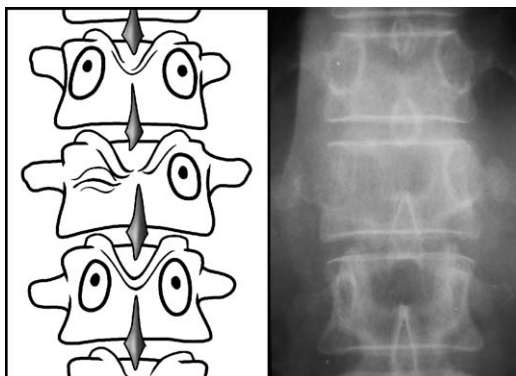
Pedicle erosion “winking owl” sign, the most common plain film finding in patients with symptomatic spinal metastasis.
